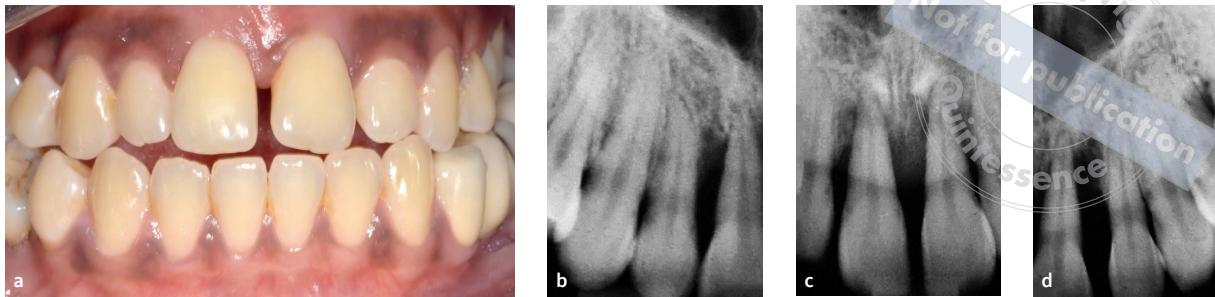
to d Clinical and radiographic situation of a 25-year-old patient diagnosed with stage IV periodontitis with pathologic tooth migration (spacing and flaring). At initial exam before step 1 and 2 of periodontal therapy (T_0 = baseline) (a).
